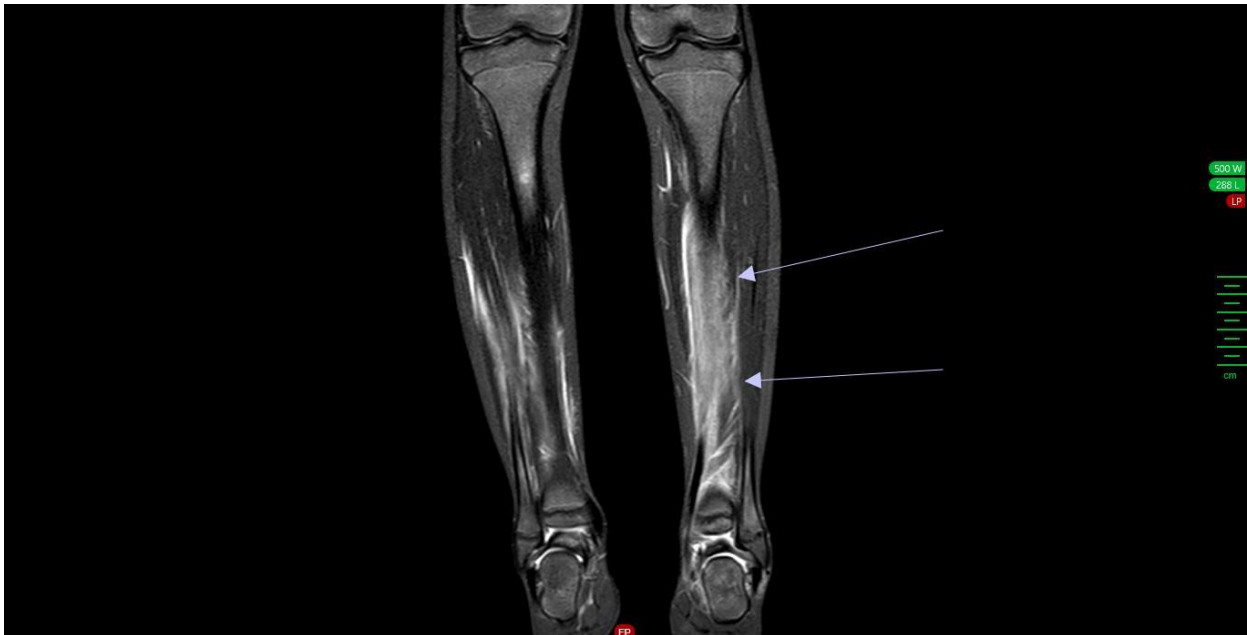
MRI finding: Bone increased signal intensity
